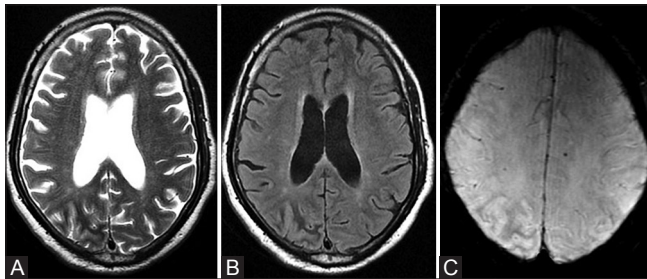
(A-C): Axial T2W (A) FLAIR (B) and SWAN (C) images of the brain show cortical hyper-intensity on T2W, FLAIR, and SWAN images involving right parietooccipital region with adjacent subcortical white matter hypo-intensity
